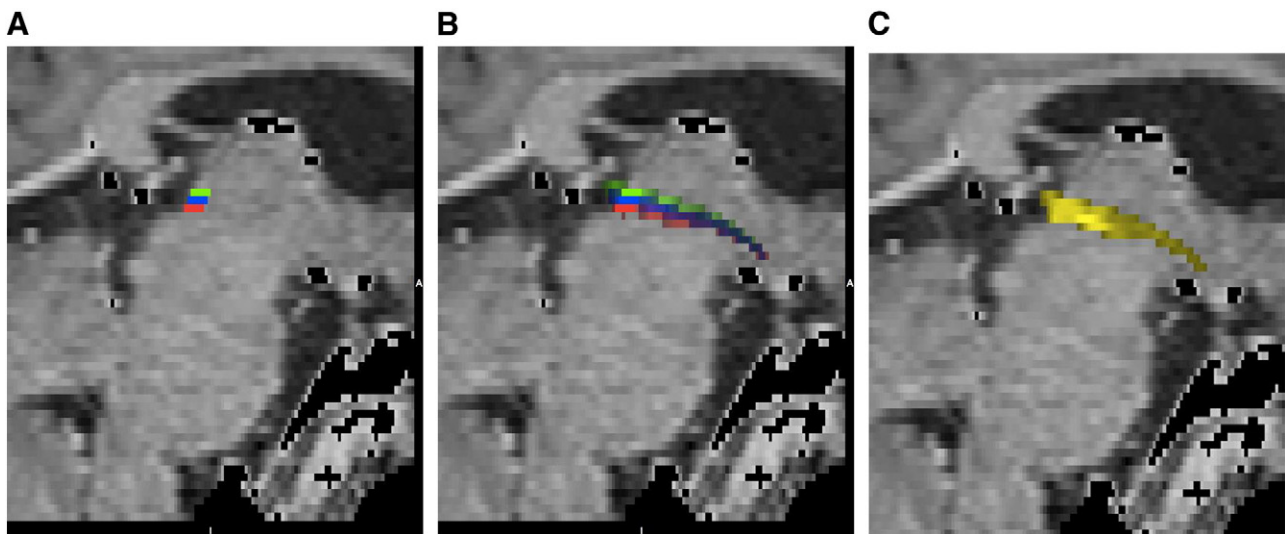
Tractography based on axial seed slice. The habenula is visible as a protrusion into the ventricle in typically three consecutive axial slices as shown in green, blue, and red, respectively, in a sagittal reformat of the T1-weighted series (A). Note that these habenular seed regions are initially divergent; however, moving anteriorly away from the seeds, the tracts begin to converge (B). Creating a larger seed region spanning the three individual seed regions that lie in different axial planes has ultimately widened the region of uncertainty of the SM (C). (For interpretation of the references to color in this figure legend, the reader is referred to the web version of this article.)
